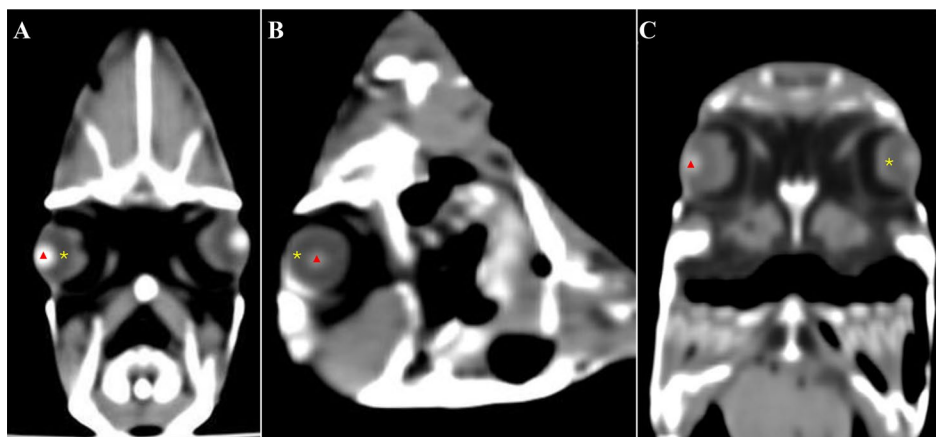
Computed tomography of the head of a Nile tilapia in axial (A), sagittal (B), and coronal (C) planes. Note the cornea and lens (red triangle) with hyperattenuating density, and the vitreous chamber (yellow asterisk) with hypoattenuating density.
